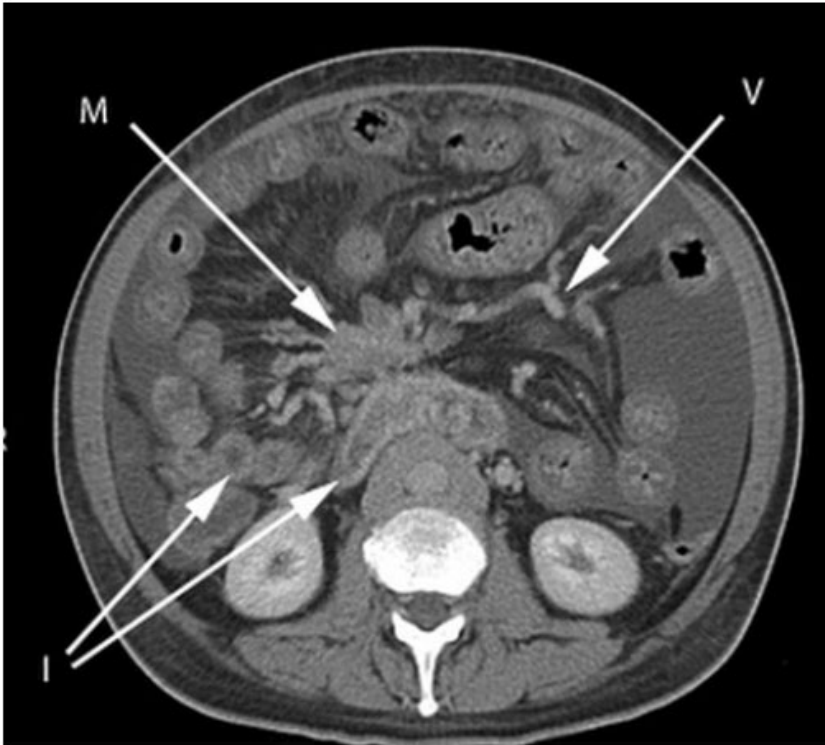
Computed tomography (CT) scan performed before stenting of the superior mesenteric vein in case 1. The large mesenteric mass is shown (*arrow; M*), as are dilated collateral veins (*arrow; V*) and loops of small intestine with thick wall (*arrows; I*)
